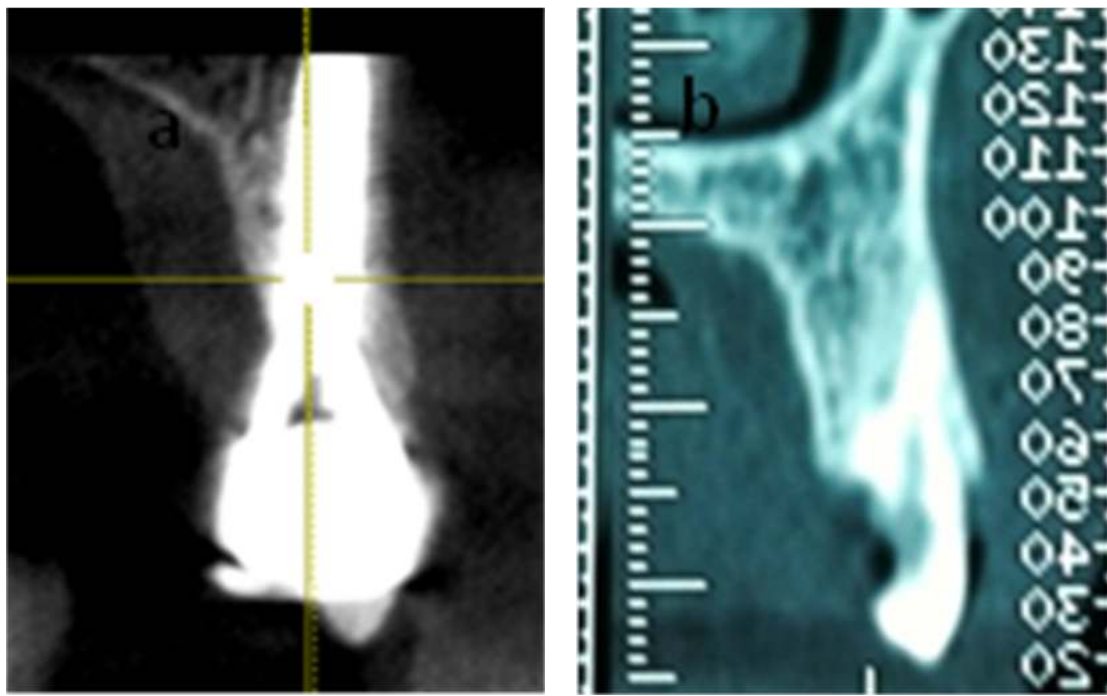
(A). CBCT (Cone Beam Computed Thomography) control 12 months after loading. Buccal bone around the implant is preserved although there has been an alveolar bone resorption secondary to tooth extraction. (B). shows to dental scan and alveolar bone volume prior to the dental avulsion
